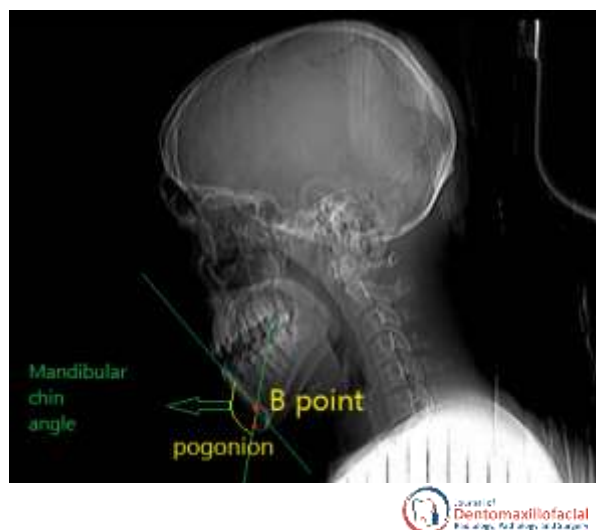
Measurement of the mandibular chin angle in scout view of CT images
